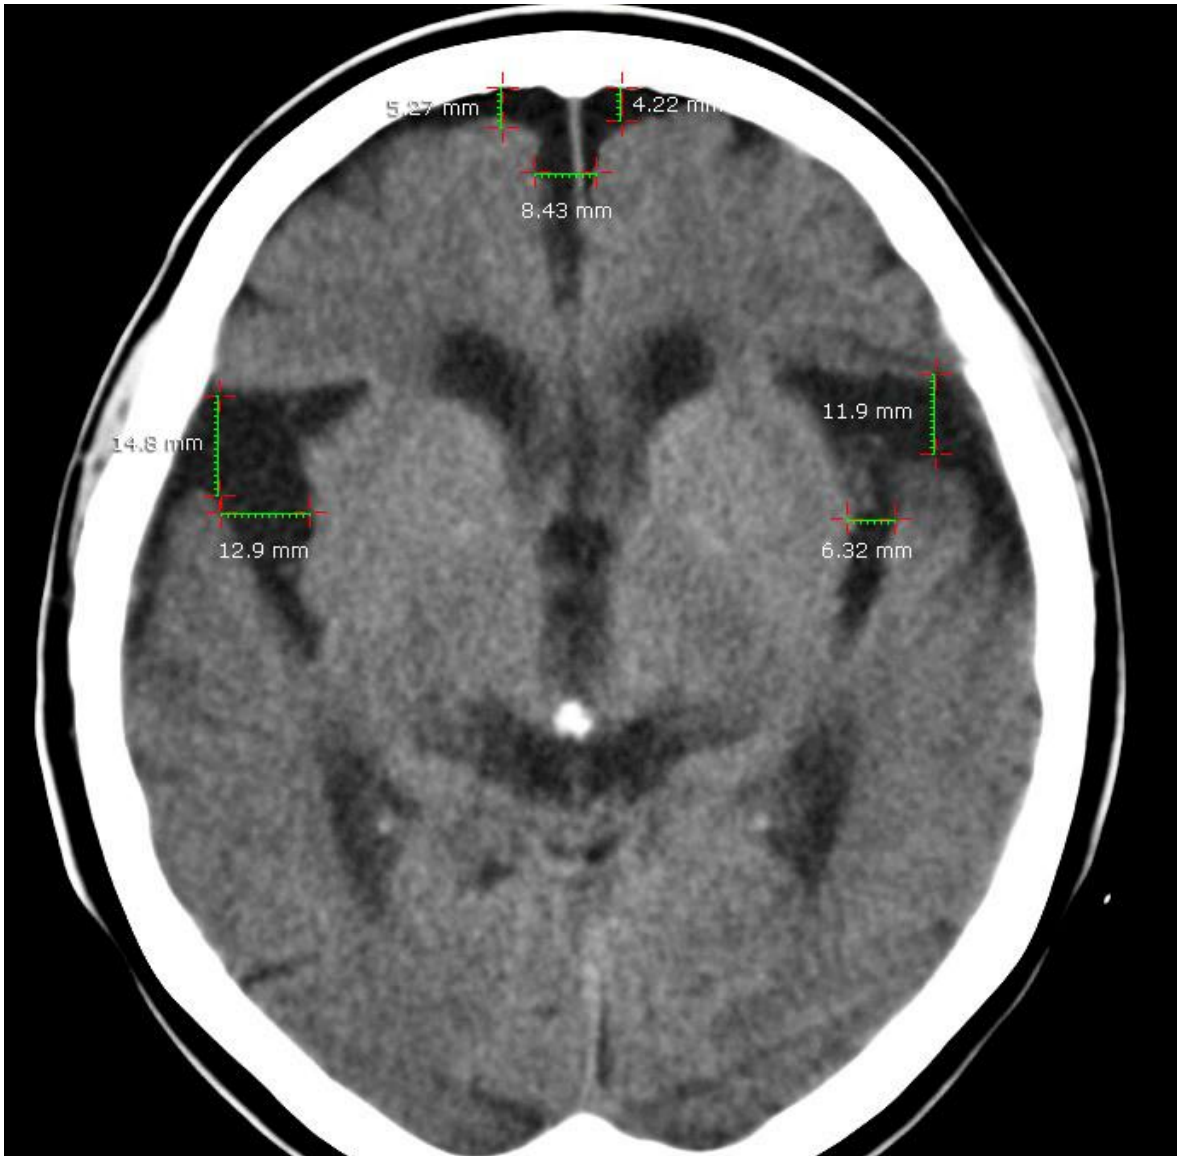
Computed tomography image of the simple skull of a 75-year-old patient that came to the imagenology ward of Juan Bruno Zayas Alfonso Hospital , without neurologic focalization signs, it showing signs of cerebral atrophy, with deepening of the grooves at the frontal level (5.27 and 4.22 millimeters respectively), of the anterior portion of the interhemispheric fissure (8.43 millimeters) and dilation of the grooves of Silvio (11.9 and 14.8 millimeters on both sides) and Rolando (6.32 and 12.9 millimeters on both sides).
